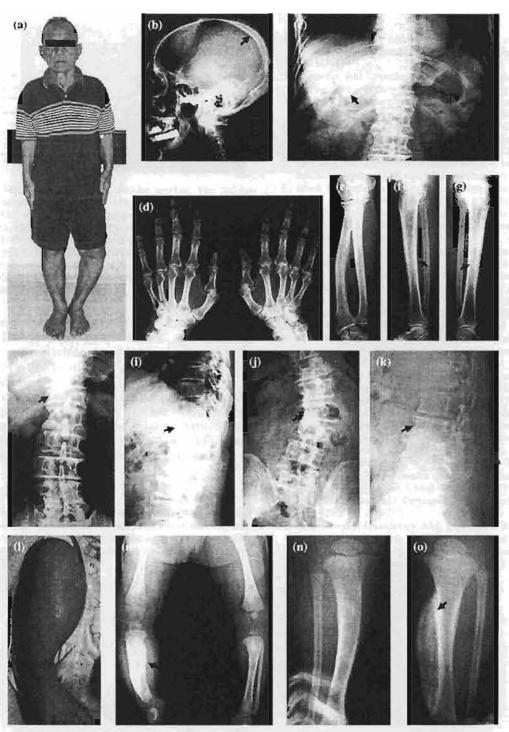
Clinical and radiological features of affected individuals. (a) Photograph of the oldest individual (1-3) with Caffey disease. Radiographs of patients 1-3 (b-i), 11-2 (j, k), and the proband, 111-15 (1-o) showing (b) cortical thickening of the cranial vault (c) ribs with paddle-like shape (d) hands with short netacarpals (e) angular deformity with cortical thickening of the radius (f, g) anterior bowing with cortical thickening of the right and left tibias respectively (h, i) kyphoscoliosis with compression fracture of T12 (j, k) scoliosis with spondylosis of L2. Photograph of the proband (l) showing swelling of the right leg, which is matched to the radiograph (m) showing periosteal elevation and cortical thickening of the diaphyses of the right tibia. Radiographs of bilateral legs showing (n, o) cortical hyperostosis with anterior curvature of the right tibia and periosteal elevation and cortical thickening of the left tibia, respectively. Arrows indicated the affected bones.
